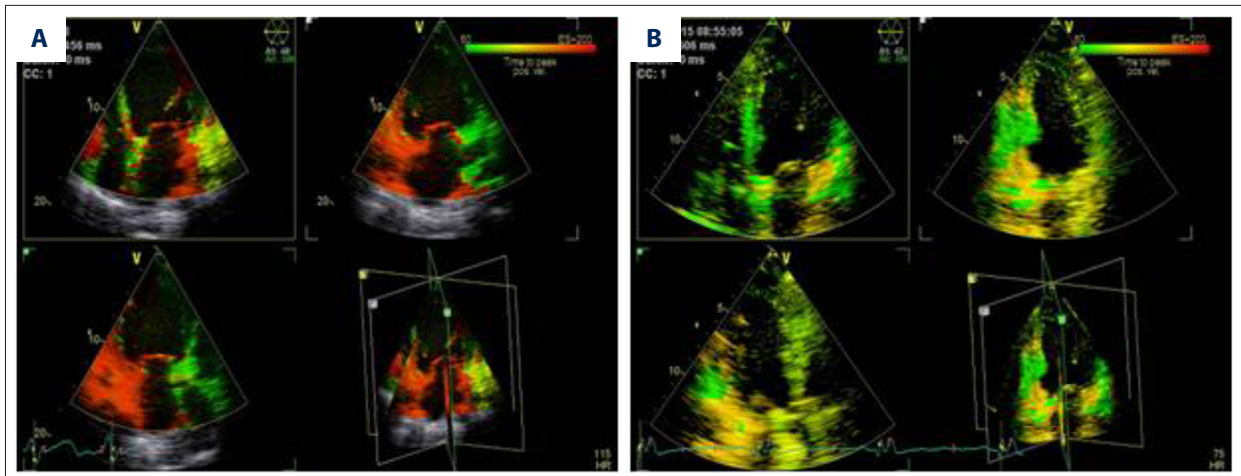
Echocardiographic synchronous imaging showed a significant improvement in postoperative synchronization in the 1 case with chronic heart failure implanted with a dual-chamber pacemaker (Medtronic Relia RED01) to implement biventricular resynchronization through rate-adapted atrioventricular delay. (A) Preoperative ventricular septum, inferior wall delayed in the lateral wall. (B) Postoperative left ventricular synchronization was good.
